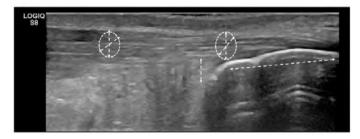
Representative scheme of the measurements taken during the ultrasound examination of the Achilles tendon.
